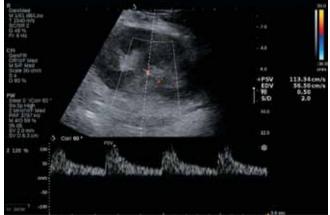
Ultrasound image of a renal transplant of clinical case $N_{\Omega} 2$
